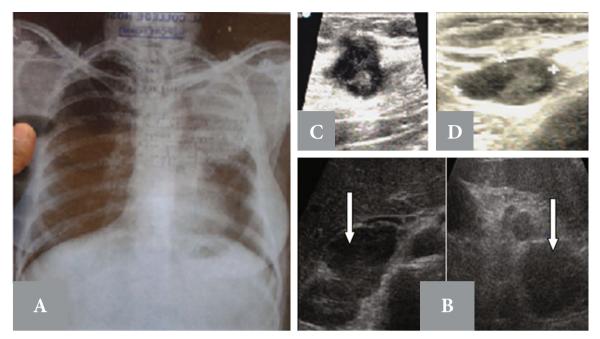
A) Chest X-ray showing metastasis in the left upper lobe. B) Metastasis in bilateral adrenals, C) abdominal wall nodule and D) right thigh nodule.
